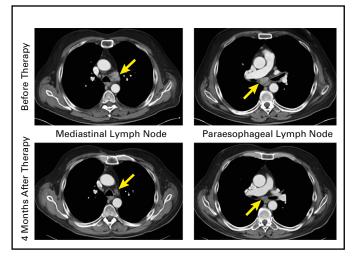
Computed tomography scans of patient 9 with metastatic esophageal cancer before and 4 months after T-cell therapy.
